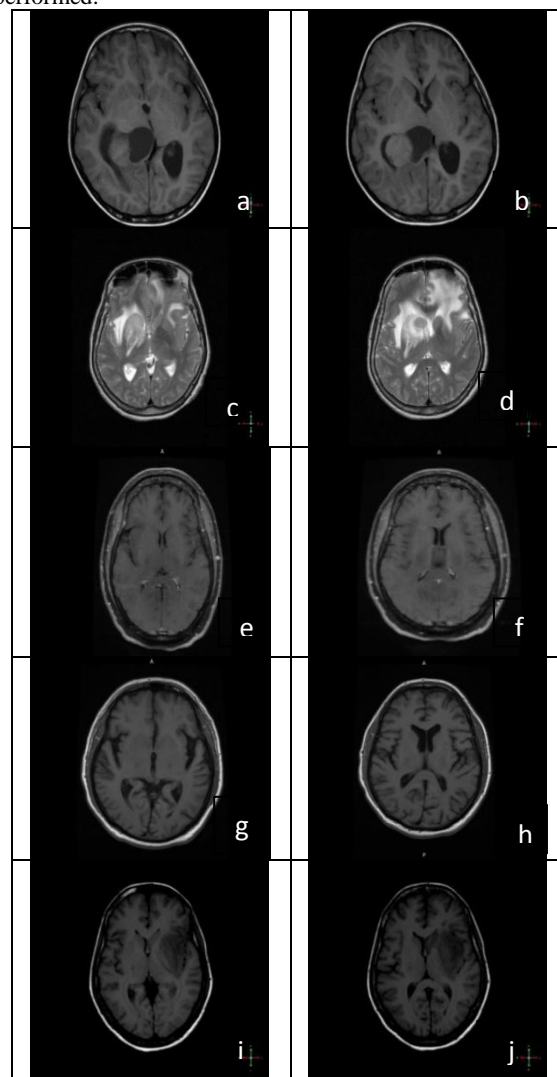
Original MR T1-weighted brain images. a, b- Astrocytoma; c, d-Glioblastoma; e, f- Metastatic; g, h- Pituitary macro; i, j-Glioma
